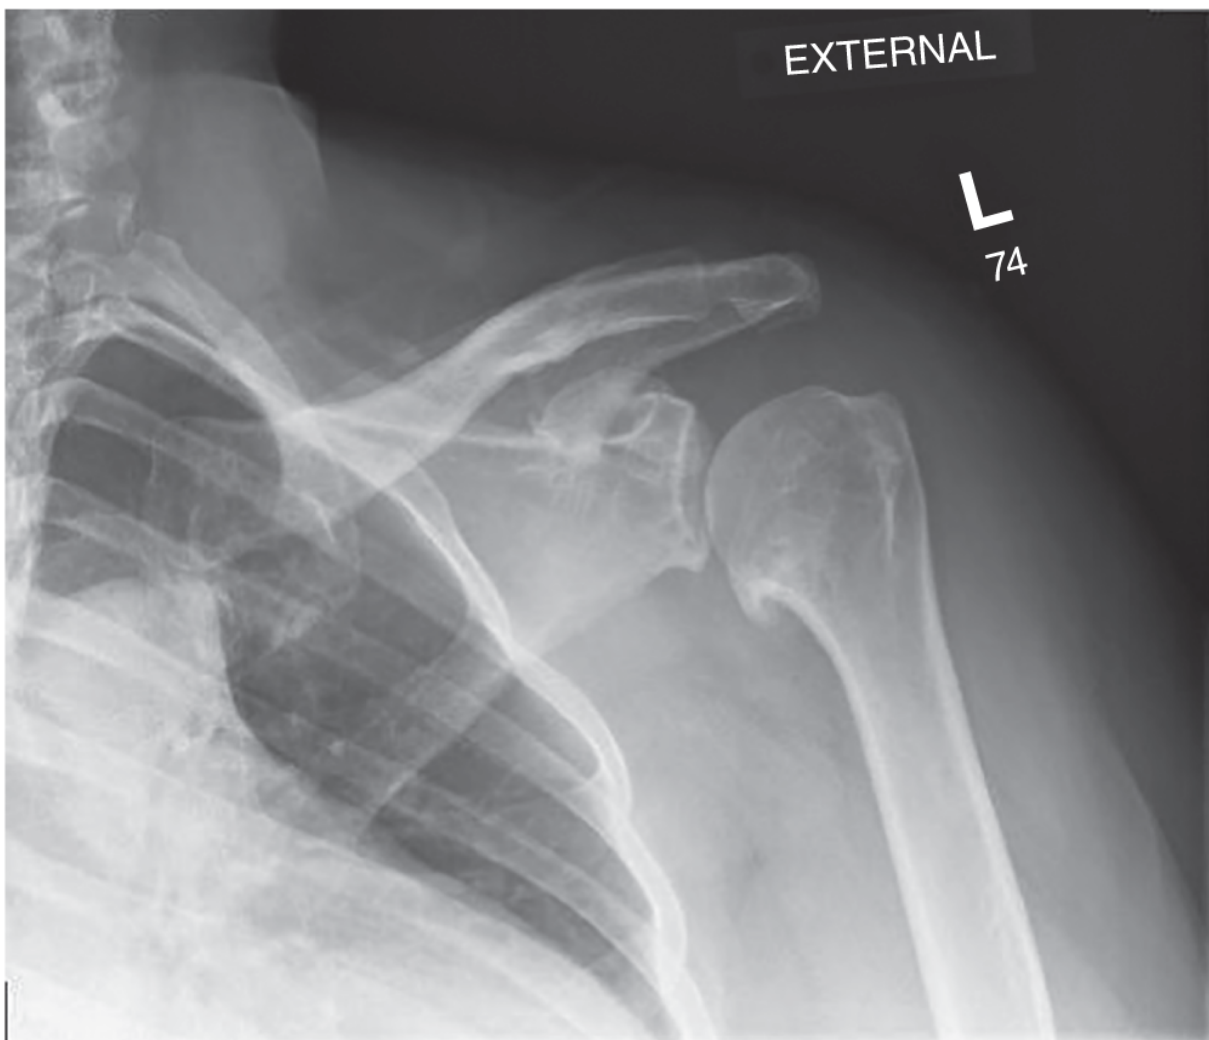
True AP radiograph of the left shoulder shows joint space collapse, subchondral sclerosis, inferior humeral osteophytes and medialization of the humerus without signs of rotator cuff insufficiency. Source: Chad Myeroff, Michael Knudsen, Michael D. McKee.
